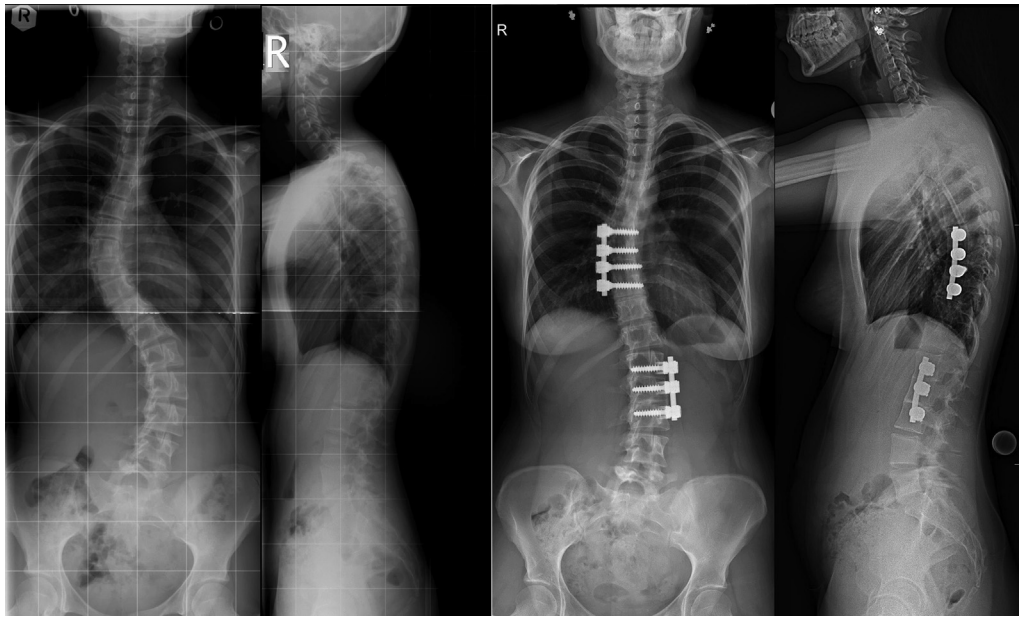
Pre- and postoperative radiographs in anterior instrumentation with correction from 49° Cobb angle to 26° in lower curve and 50° to 20° in upper curve 5 years postoperative.
